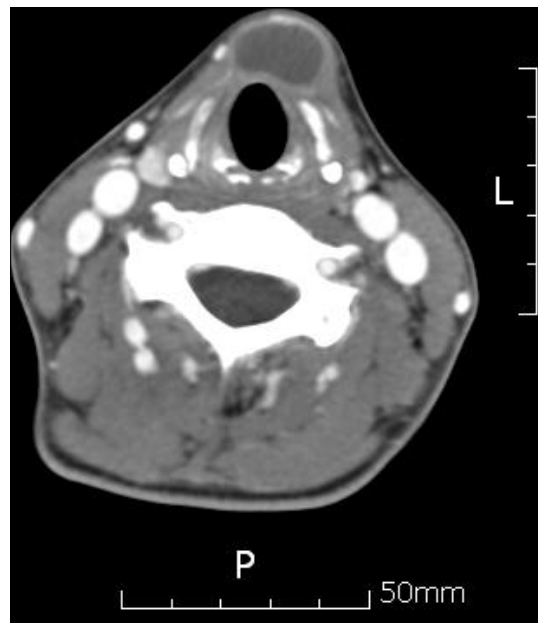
Neck CT shows about 1.9 × 1.2 cm sized well-defined cystic lesion beneath strap muscle just below the hyoid bone without solid portion.
